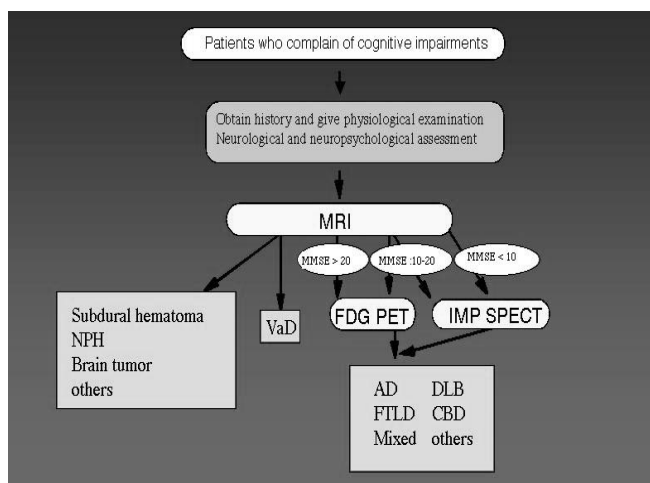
Decision tree for diagnosis of dementia at Hyogo Institute for Aging Brain and Cognitive Dementia. At my institute, mild and moderate dementias are examined with PET and severe dementia is subjected to a SPECT examination but not to a PET examination.
